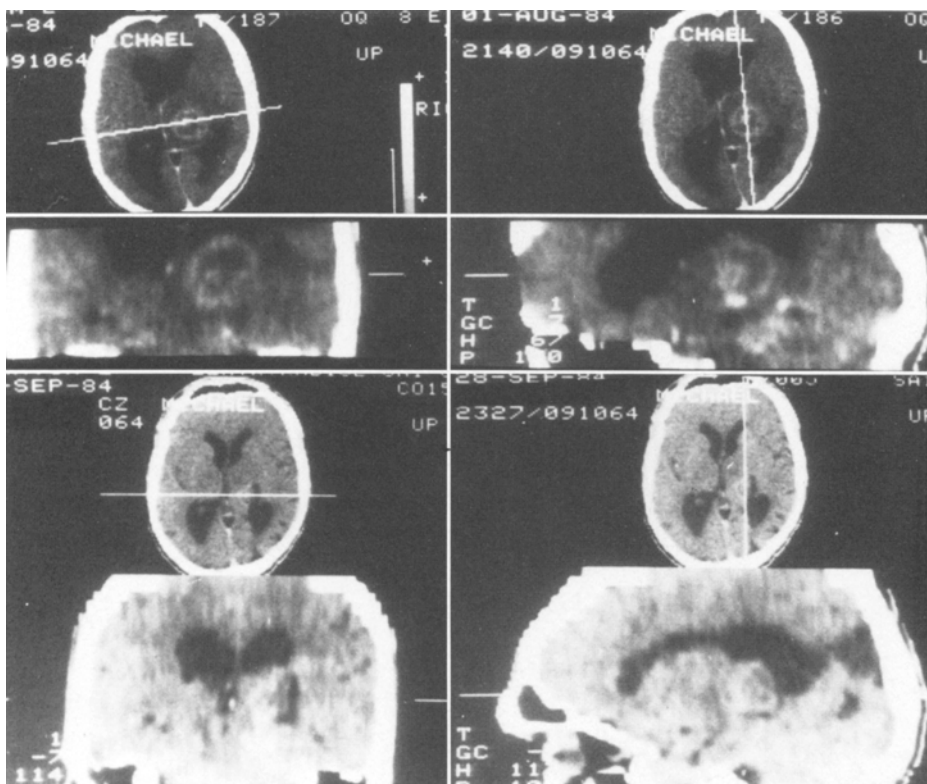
Astrocytoma III of right thalamus (M. O. 091164/1984). Pre- and post-operative CT. Intergyr-al-transsulcal-transventricular approach. Removal by ND-Yag laser and CUSA. Radiotherapy. Regression of hemiparesis and hypaesthesia. Normal after 1½ years
